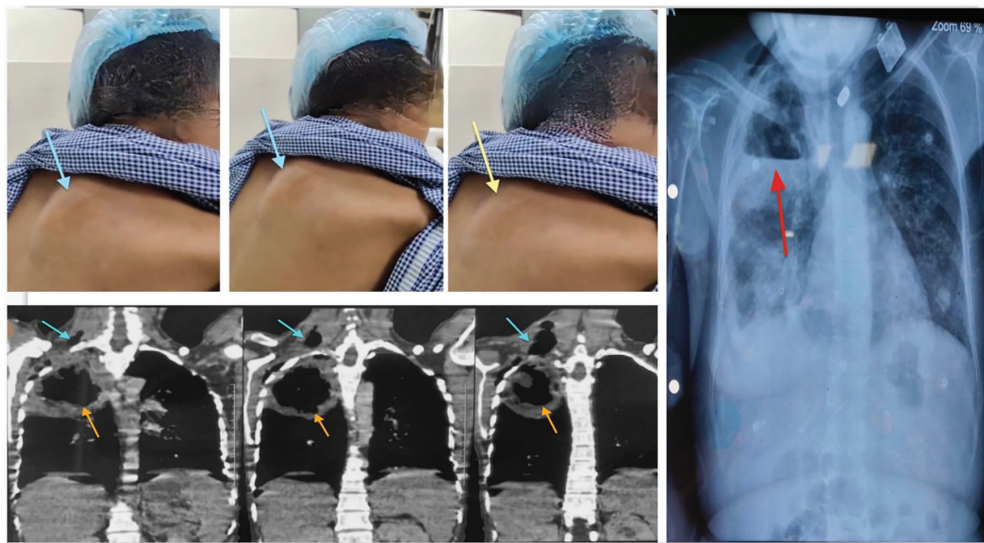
(a) The blue arrow in the first two frames shows an expansile area during inspiration. The yellow arrow shows the collapse of the same region during expiration. (b) Chest X-ray: The red arrow shows a cavitary lesion in the right upper lobe of the lung. (c) A chest CT revealed an apical cavitary lesion (orange arrows) and a communicating lesion in the subcutaneous plane (blue arrow).
